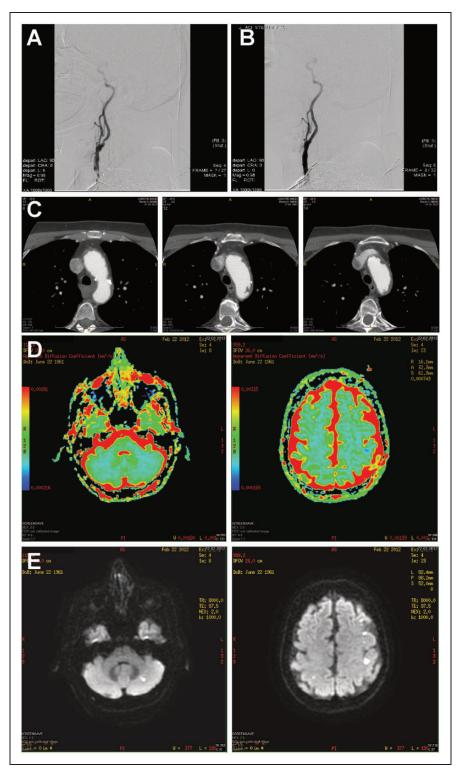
A 50 year-old female patient had significant ICA stenosis on the right side before (a) and after (b) stenting. Extensive soft plaques with some calcified components were observed on the primary AA slices (c). ADC (d) and DWI (e) images demonstrate several fresh ischemic lesions on the contralateral side. Some new lesions were found on the ipsilateral side (not seen) and posterior fossa. AA: aortic arch; ADC: apparent diffusion coefficient; DWI: diffusion-weighted imaging; ICA: internal carotid artery
